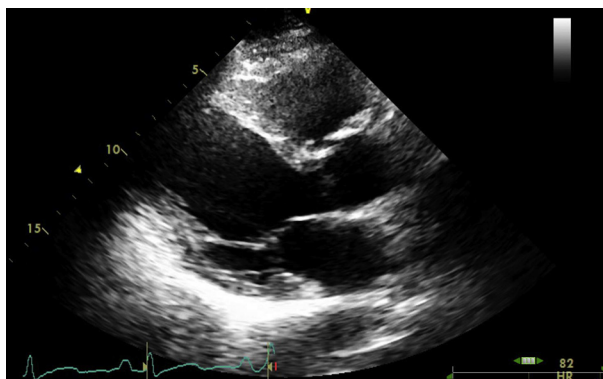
Parasternal long-axis view after immunosuppression therapy revealing normal left ventricular size and resolution of the pericardial effusion.
